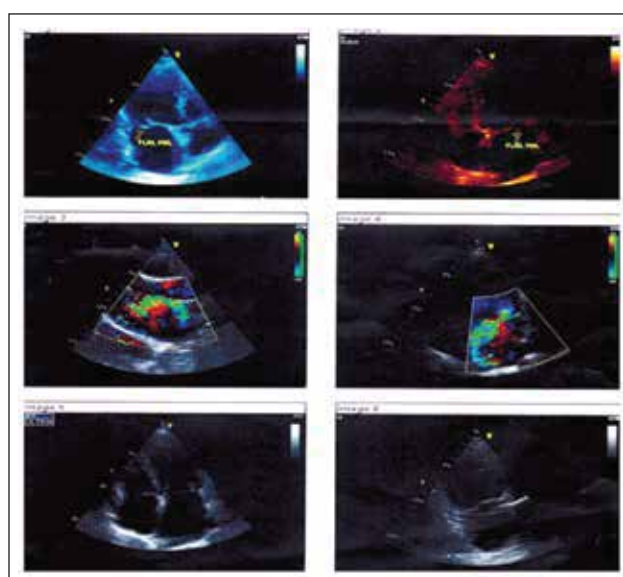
Echocardiographic finding before treatment showing flail posterior mitral leaflet (?due to ruptured chordae) with severe mitral regurgitation (MR), mild dilated left atrium (LA), pulmonary artery systolic pressure (PASP)=70 mm Hg, and left ventricular ejection fraction (LVEF) 50%.
